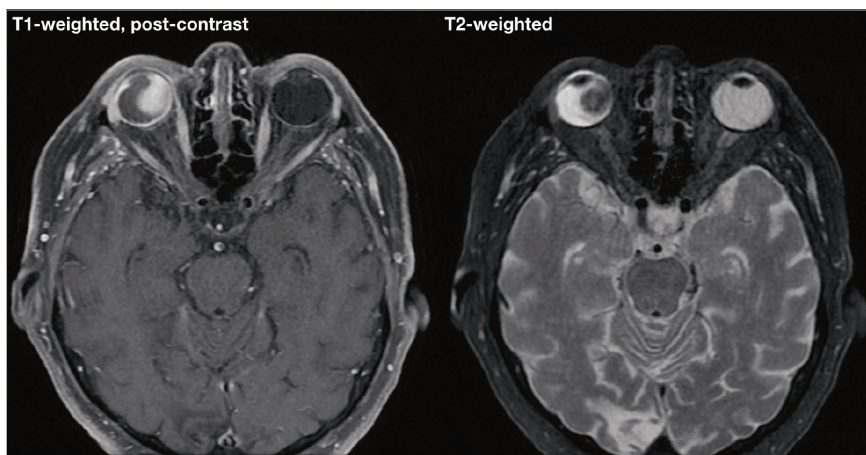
Magnetic resonance imaging showing hyperintense enhancing mass on T1-weighted, fat-suppressed image and hypointense mass on T2-weighted image within the right eye.
